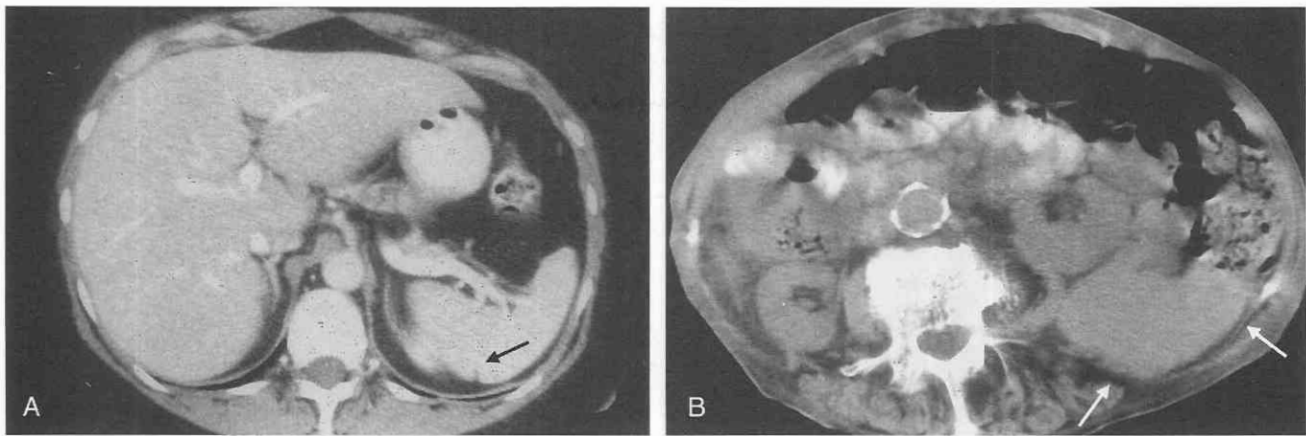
Normal splenic variants. A, CT scan showing splenic cleft (arrow). B, CT scan showing retrorenal spleen (arrows). Note how the splenic location would make a left renal biopsy difficult.
